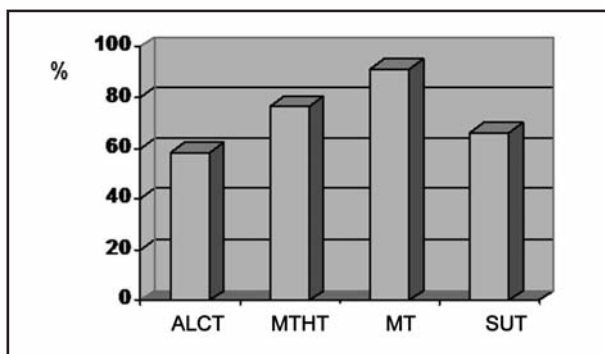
Relative percentage frequency (%) of degree of homogeneity employing the different techniques: active lateral condensation technique (ALCT), modification of Tagger's hybrid technique (MTHT), Microseal technique (MT) and ultrasound technique (UST).
